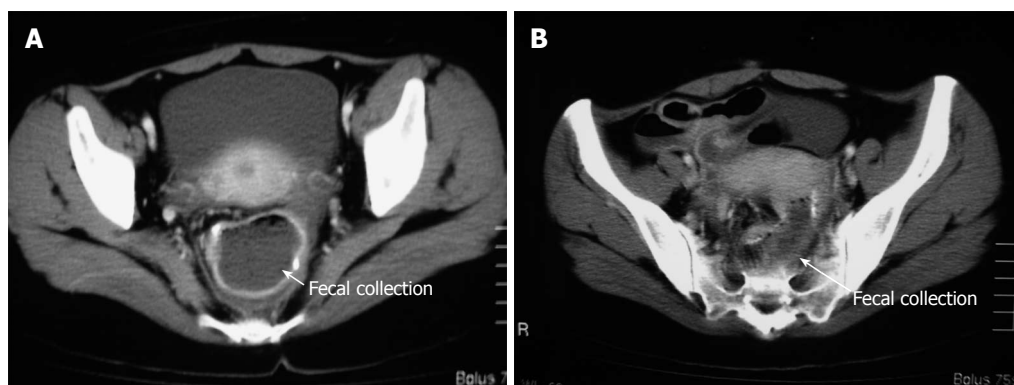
Abdominal computed tomography showing a massive collection of feces in the pouch (A) and proximal ileum (B).
